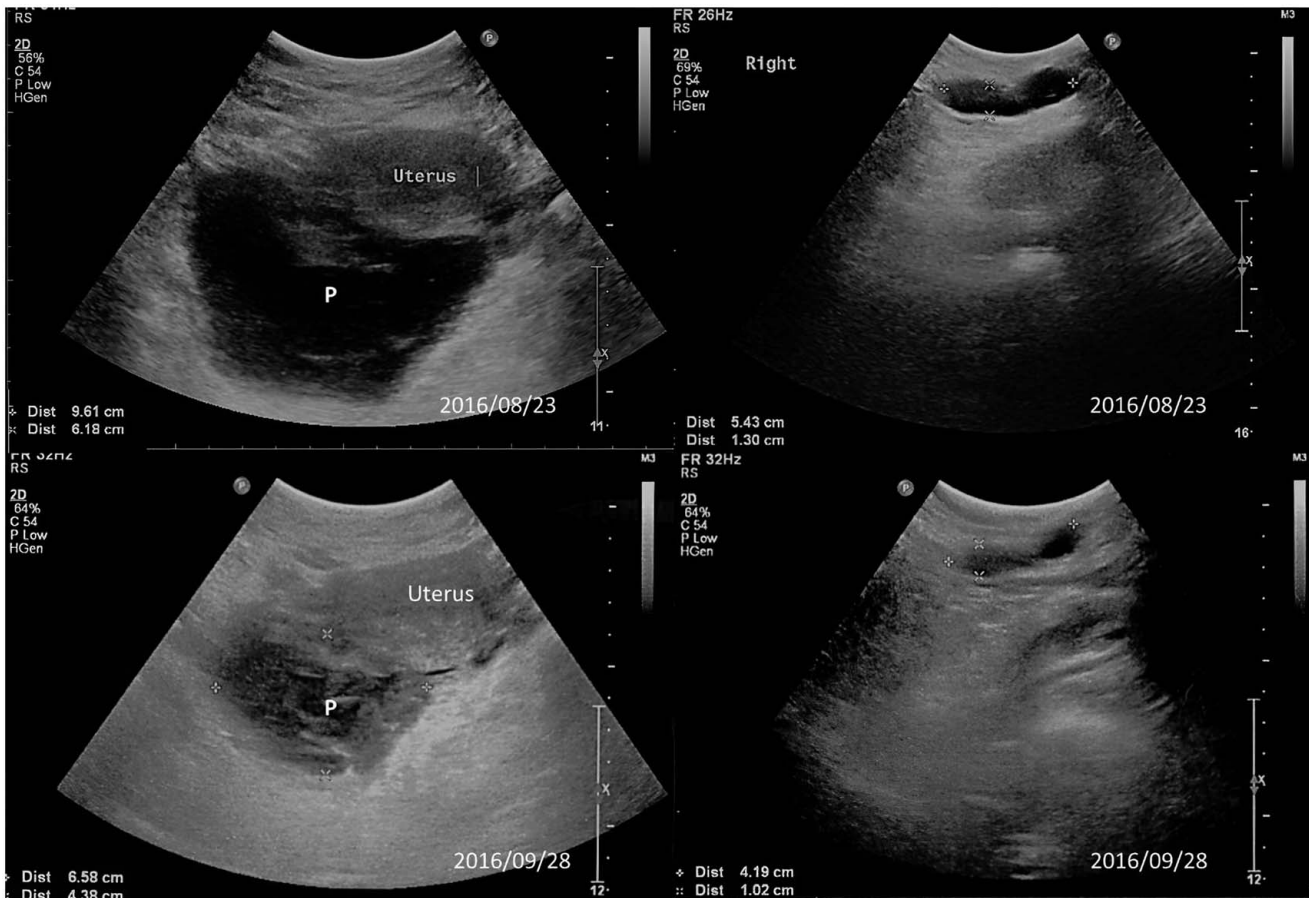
Postoperative transabdominal sonography on 2016/08/23 showed one 9.61 × 6.18 cm pelvic cyst (P) (Fig. 1A) with one 5.43 × 1.30 cm inguinal cyst (Fig. 1B). Sonography on 2016/09/28 showed pelvic cyst (P) 6.58 × 4.38 cm (Fig. 1C) and inguinal cyst: 4.19 × 1.02 cm (Fig. 1D).
